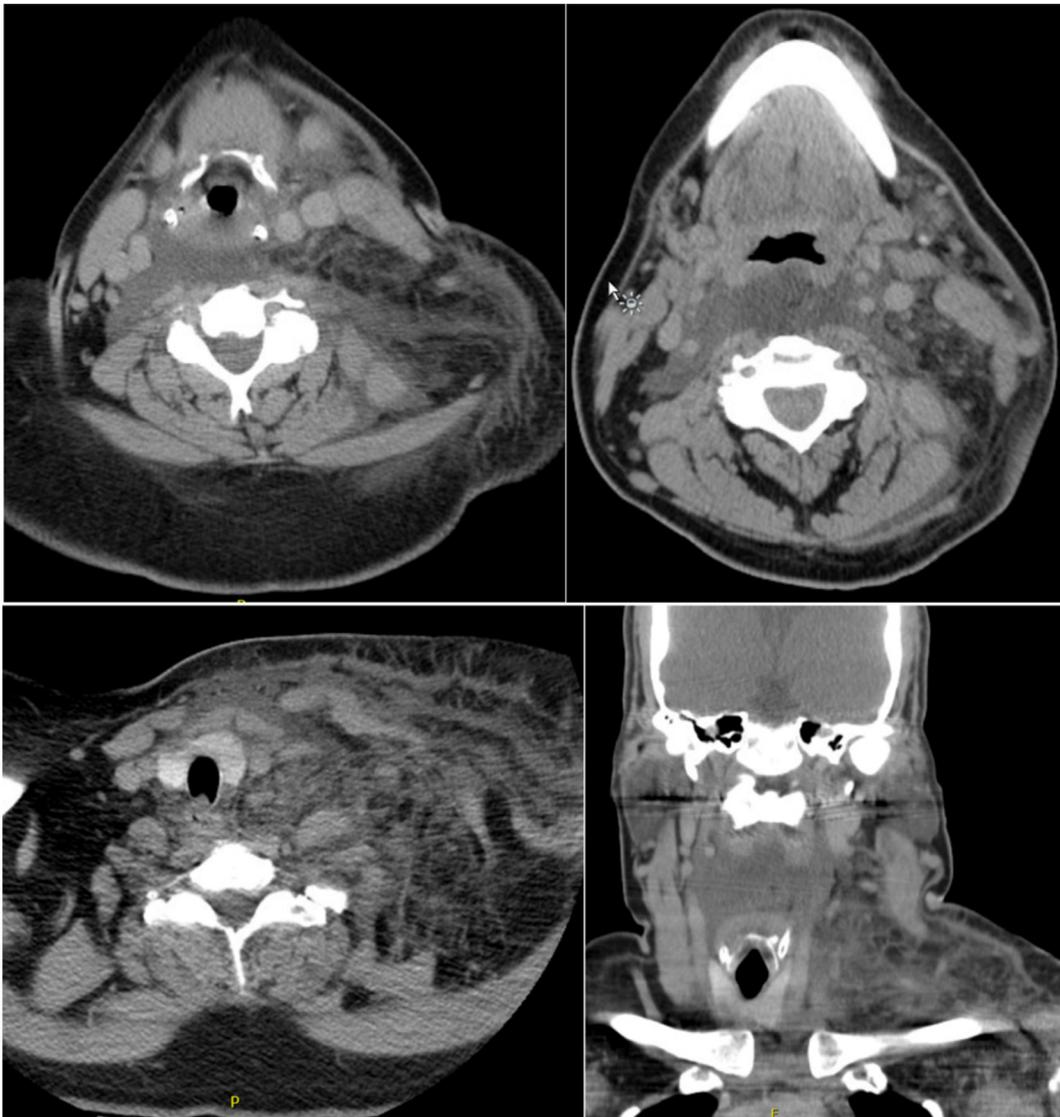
Representative axial and coronal sections of a pre-operative CT neck with contrast demonstrating infiltrative changes and retropharyngeal fluid.
